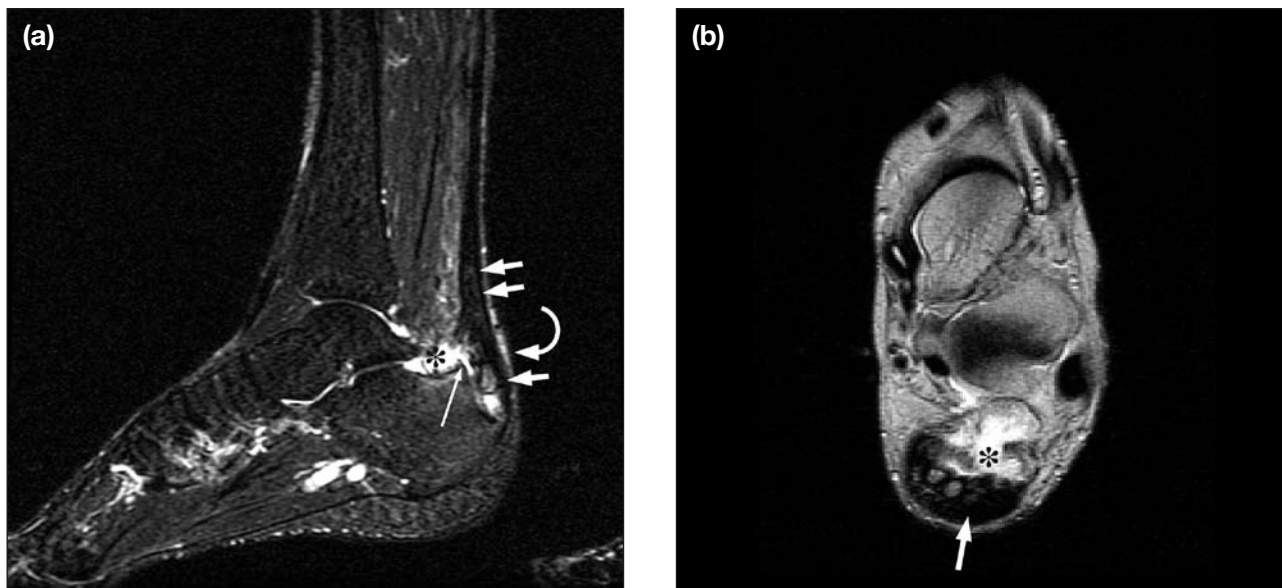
(a) Sagittal T2-weighted short tau inversion recovery; and (b) axial proton density images showing Achilles tendinosis with increased signal and ossifications at the insertion (short arrows), distension and increased signal of the retrocalcaneal bursa indicative of retrocalcaneal bursitis (asterisk), increased signal superficial to the Achilles tendon representing retro-Achilles bursitis (curved arrow), and bone marrow oedema of the protuberance of the bursal projection (long arrow).
